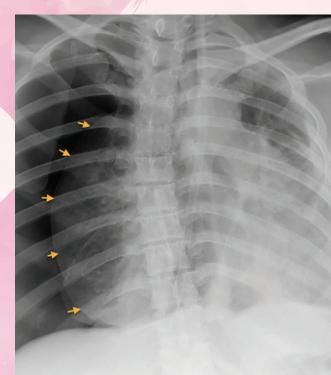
Chest radiography displayed a right-sided pneumothorax (arrow heads).
